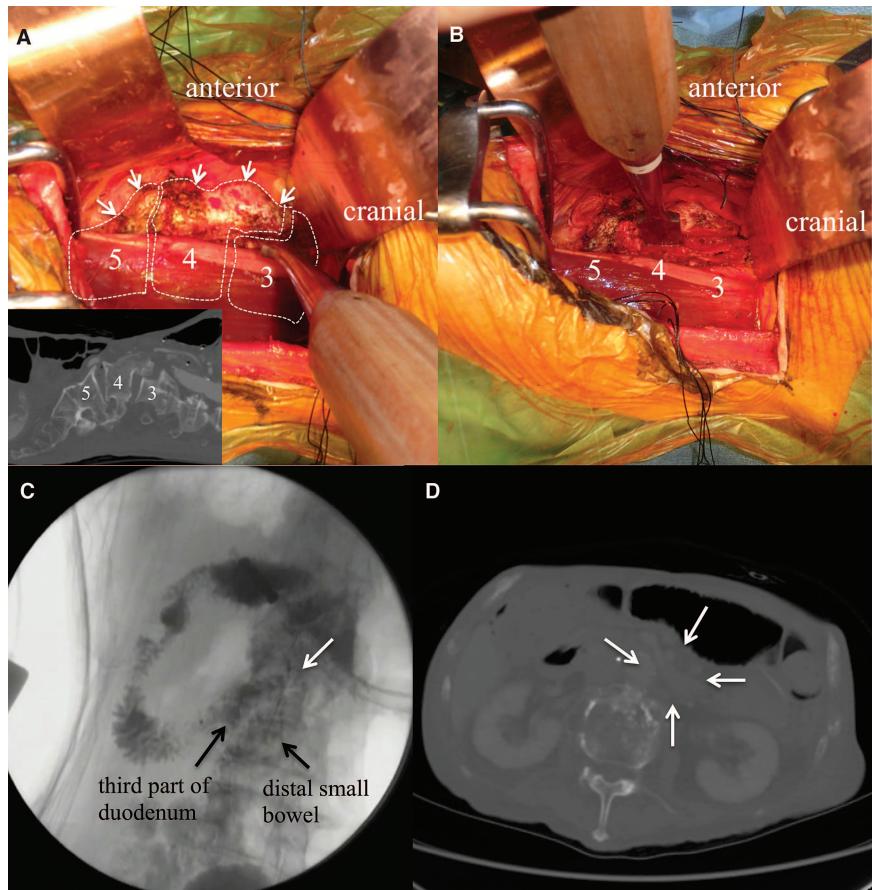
A, B, Intraoperative findings before resection of lumbar osteophytes (A) and after resection of lumbar osteophytes (B). A, Numbers 3, 4, and 5 with white dashed lines indicate the shapes of each vertebral body (L3–5). Arrows indicate the osteophytes. Inset reveals the sagittal CT image of the same site. C, A gastrografin study via a nasoileum tube showing smooth passage over the preoperative narrowed area. The white arrow shows the narrowed area. D, Postoperative computed tomography scan showed no residual osteophytes. The arrows show the absence of residual osteophytes.
